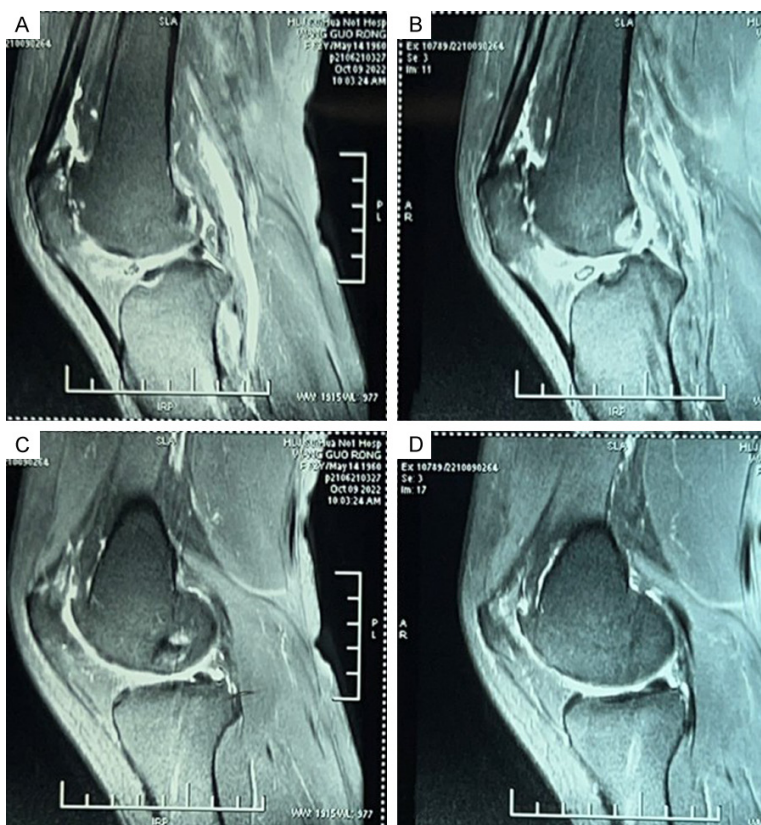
Magnetic resonance imaging of knee joint (no obvious meniscal injury or tear). A. No obvious tear in lateral meniscus. B. No obvious tear in lateral meniscus. C. No obvious tear in medial meniscus. D. No obvious tear in medial meniscus.
